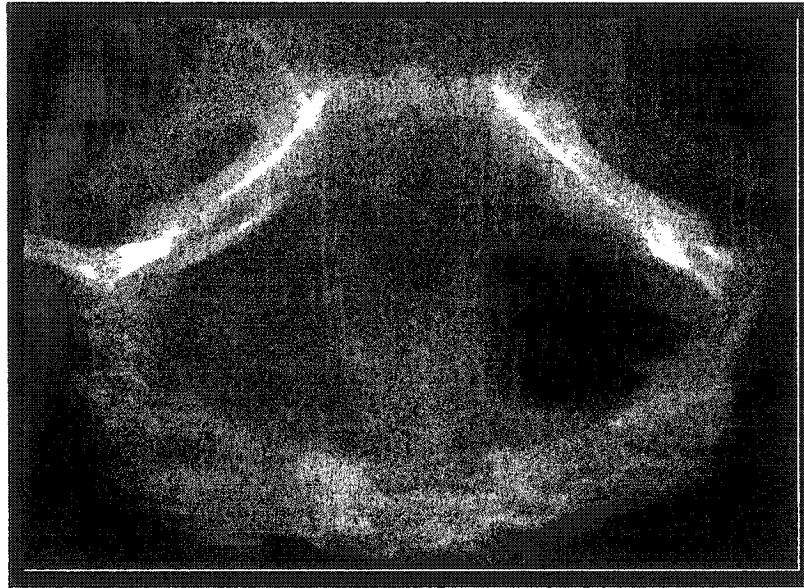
Radiograph of DBM putty and Gel only defects at 12 weeks.
